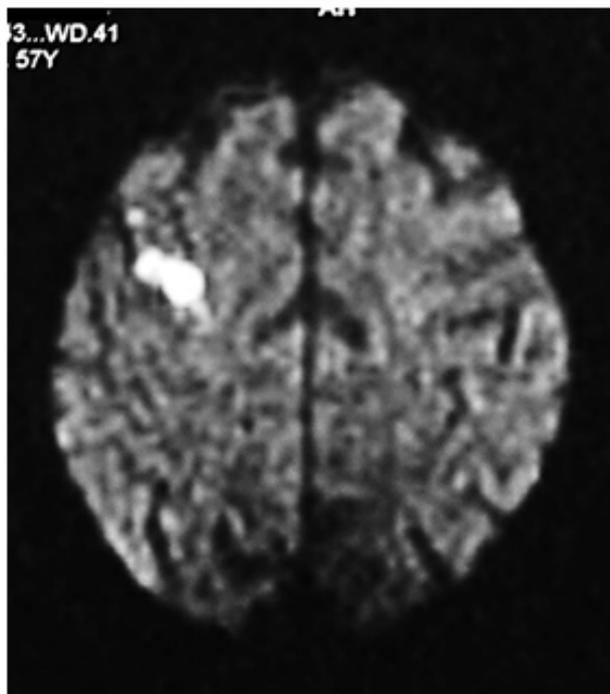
Diffusion-weighted magnetic resonance image of the brain showing an acute infarct in the right motor cortex.
